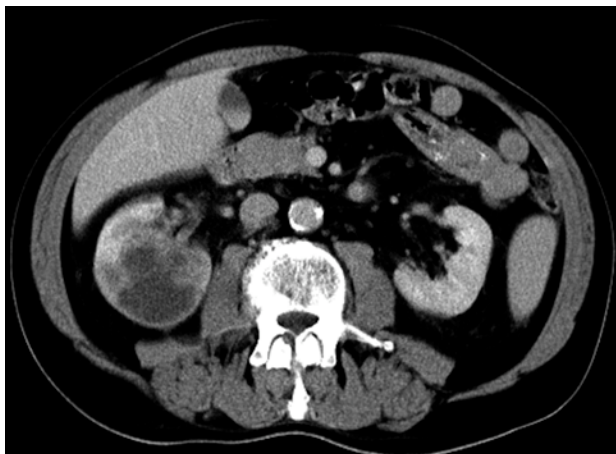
Computed tomography of the abdomen showing a 6cm unregular mass of the right kidney, resembling CDC.
